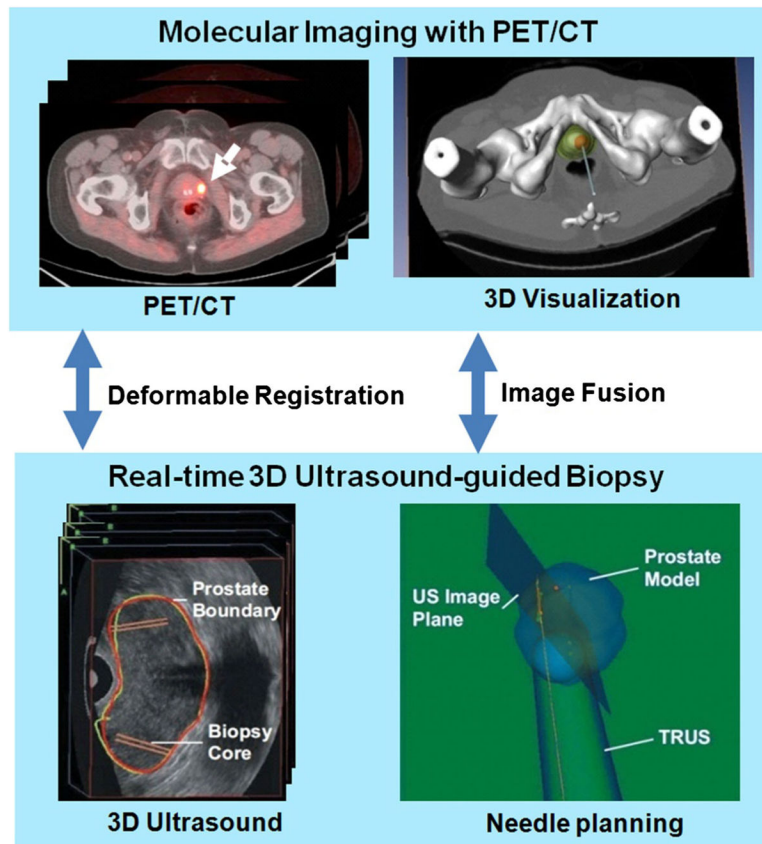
PET/ultrasound fusion targeted biopsy. *Top* the PET/CT images with fluciclovine were acquired from a human subject. PET/CT images show a focal lesion within the prostate (*white arrow*). The 3D visualization of the pelvis and the prostate were used to aid the planning of the biopsy to a suspicious tumor target. *Bottom* during biopsy, a mechanically assisted navigation device, was used to acquire 3D TRUS images from patients. The prostate boundaries on TRUS images were segmented and were used to generate a 3D model of the prostate. The 3D prostate model and real-time TRUS images are used to guide the biopsy in patients [96]
